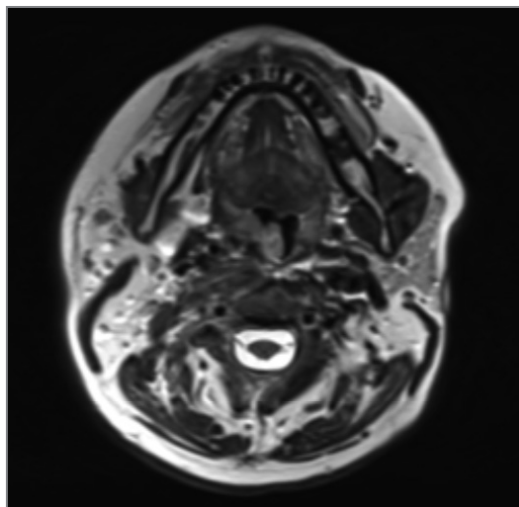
Transversal MRI (T2-weighted) shows soft tissue lesion in the right tonsillar area
